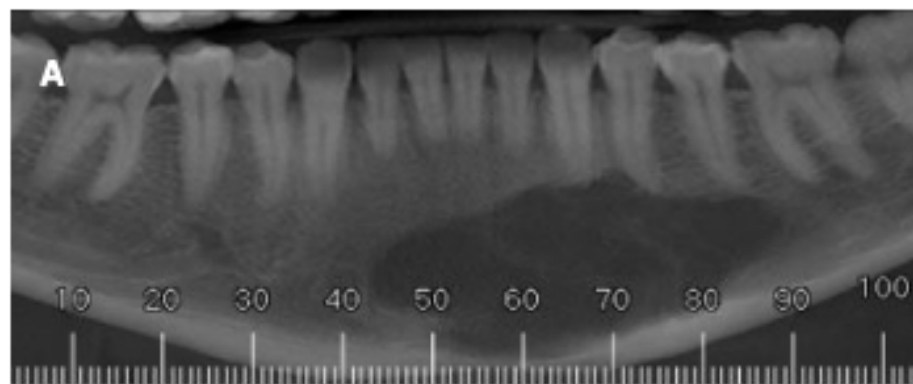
Computed tomography (June 2016) after triamcinolone applications, showing osteolytic expansion of the lesion and perforation of the buccal cortex, measuring 7 cm in diameter.
